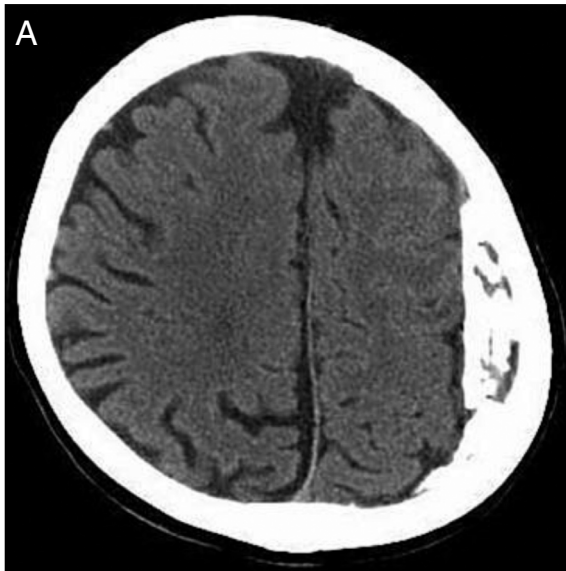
Axial image of non-contrast computerized tomography (CT) scan (A) at the time of admission revealed a left subdural mass consisting of both of calcified thick inner membrane and organized haematoma with multiple calcification. A coronal CT image (B) demonstrated a huge calcification at the left subdural region with thick hyperdense calcified margins, the so-called armoured brain.
